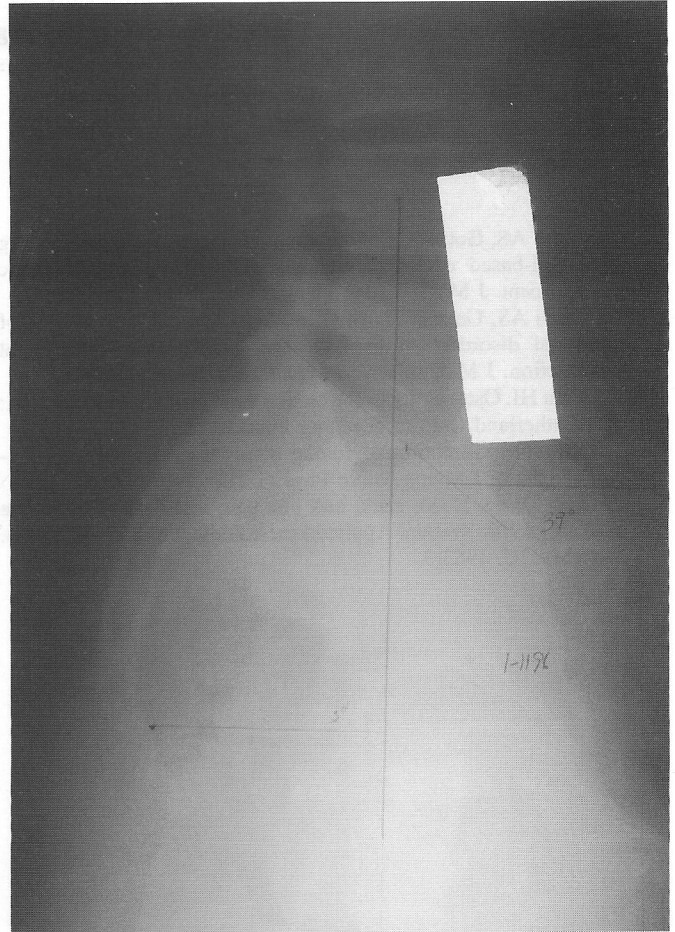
X-ray (January 11, 1996) that shows further improvement in sacral positioning.
